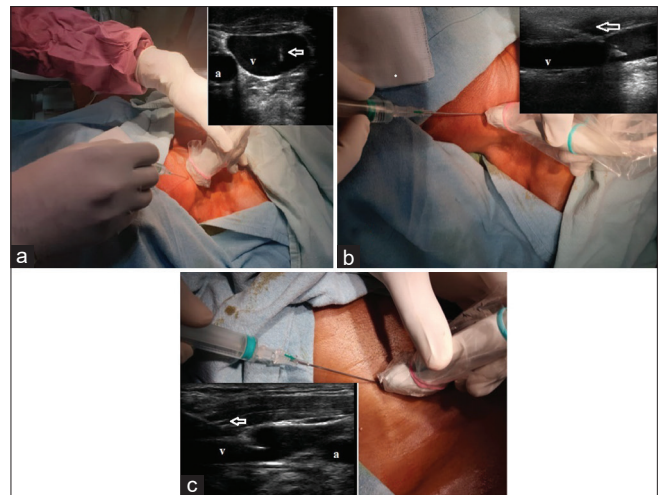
Ultrasound transducer orientation and needle insertion with corresponding ultrasound images showing the quality of needle visualized. (a) Short-axis view. (b) Long-axis view. (c) Oblique-axis view. a: Carotid artery, v: Internal jugular vein, Arrows: Quality of needle visualized
